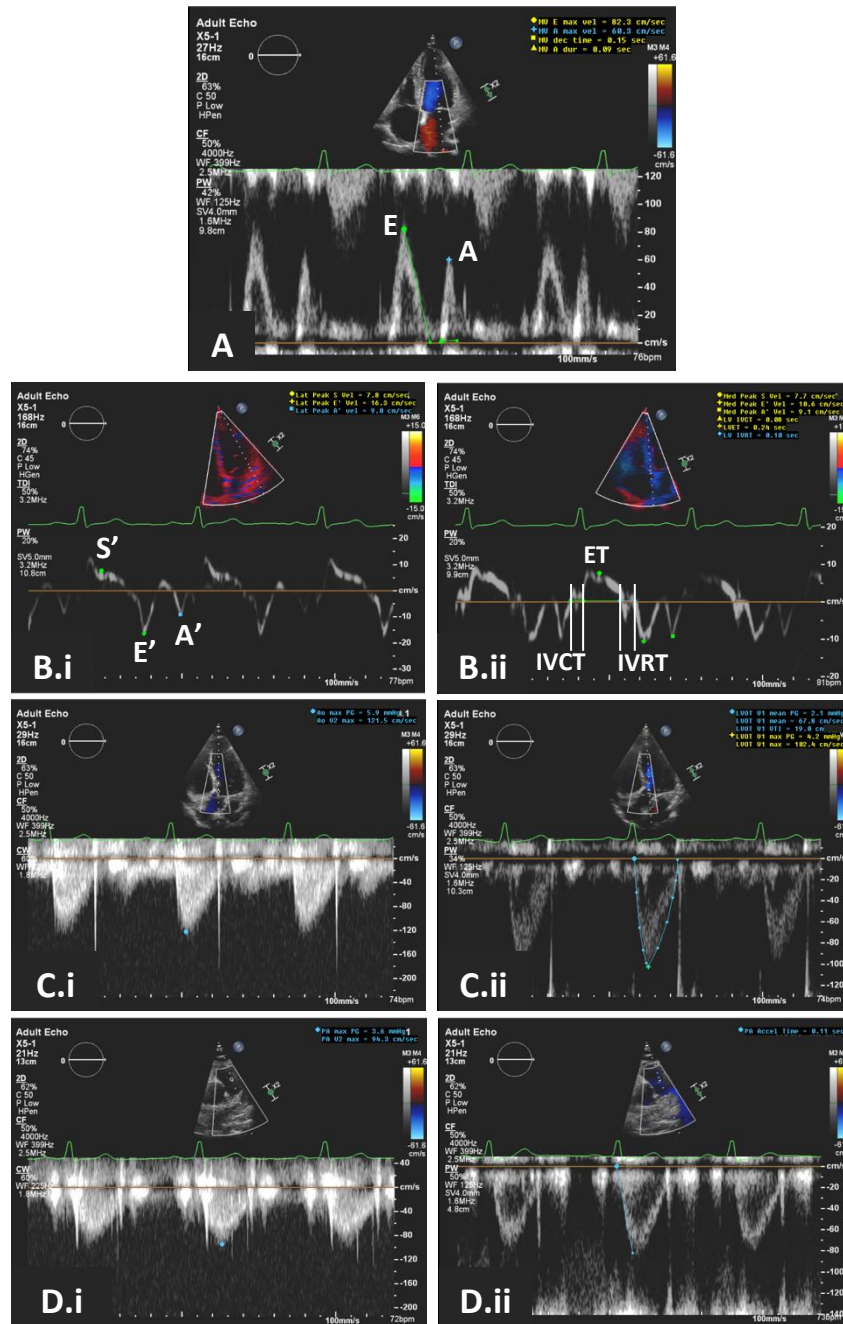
Doppler velocities assessment.
